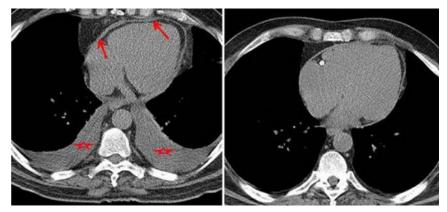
CT of the chest from a patient with transient CP, demonstrating thick pericardium (*arrows in left image*) and pleural effusion (*star*) at baseline when the patient was having symptoms of constriction, which was returned to normal thickness (*right*) after 1 month of steroid therapy.
